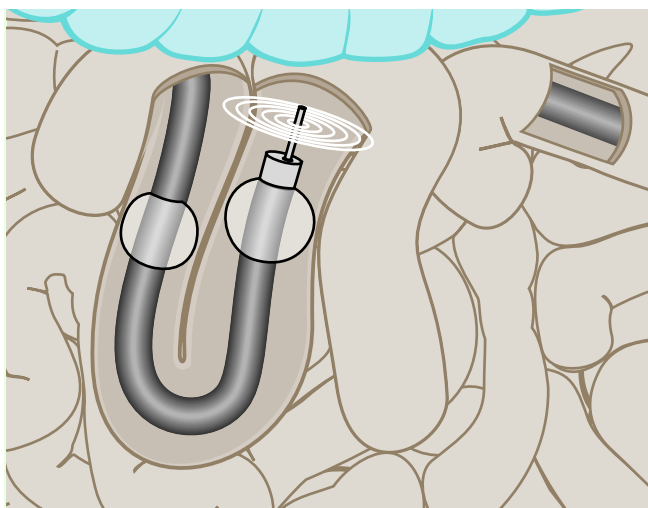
Close up of the distal end of the enteroscope with the ultrasound transducer in a bent position making ultrasound imaging difficult. In this position the ultrasound transducer rotates slowly until the bowel is straightened by retracting the enteroscope.
